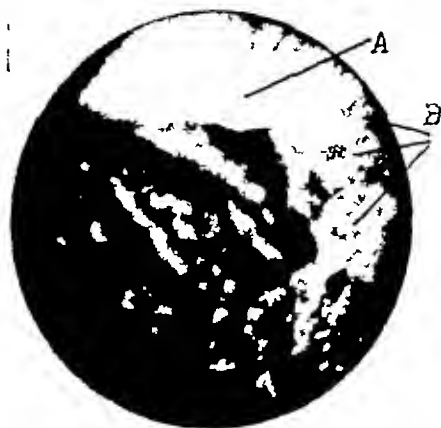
An intragastric photograph of a patient with moderately acute symptoms. The roentgen examination revealed gall bladder pathology but the stomach findings were indefinite except for showing marked spasticity near the pylorus. The photograph shows a spastic fold at A and a series of small ulcers or erosions at B which no doubt caused the stomach symptoms and produced the spasticity. From the appearance of this pathology, a resection was not deemed necessary. However the stomach was explored while doing a cholecystectomy and the lesion confirmed.
